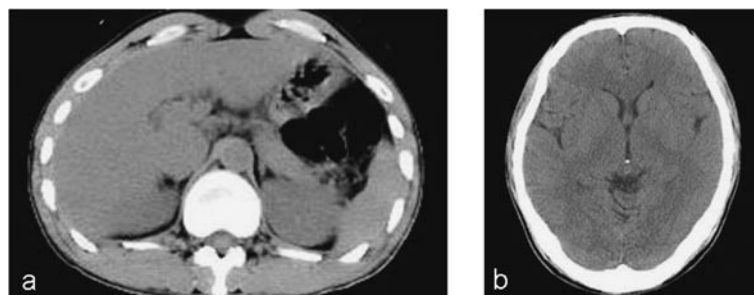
CT scan of case 2.
